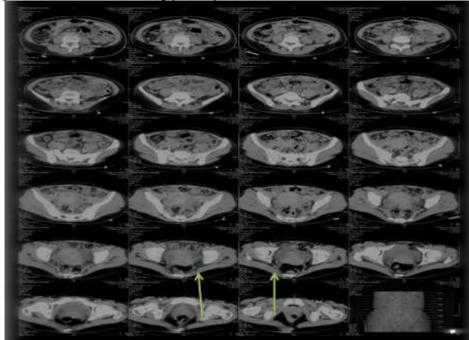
Axial CT scan showing (arrows) bilateral calculi in the distal end of both ureter.
